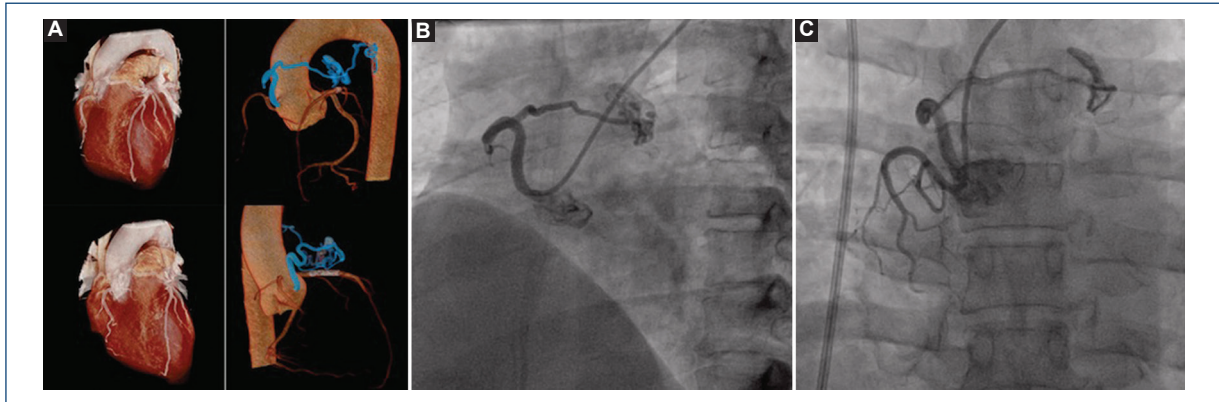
A: coronary computed tomography angiography 3D reconstruction. Vieussens' arterial ring with an additional small bronchial branch surrounding the main pulmonary artery with a large niche that communicates with the pulmonary artery and its relationship with surrounding structures (blue). B and C: initial angiography. Small right coronary artery and an independent right conus artery (B) with pre and retroconal path (Vieussens' arterial ring) with a large niche that communicates with the main pulmonary artery (contrast media delimitating the PA trunk) (C).
